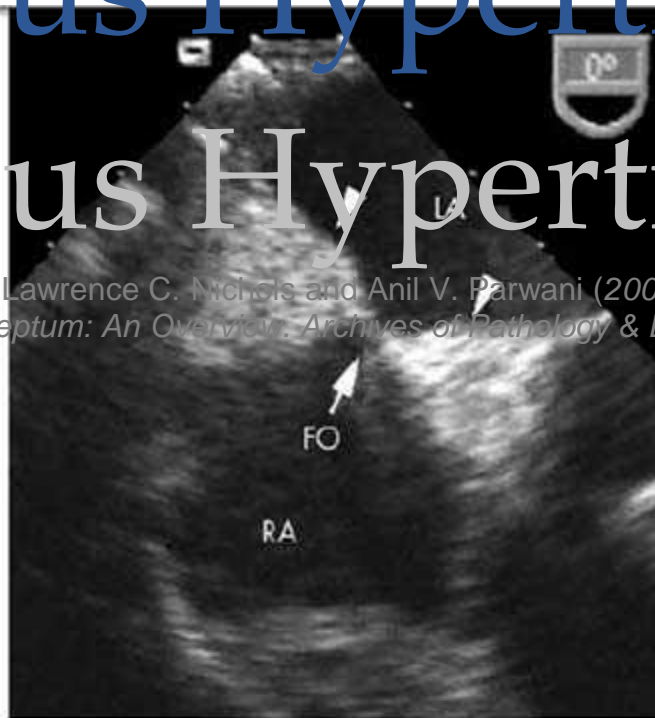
Transoesophageal echocardiogram at the mid-oesophageal level showing the classic hour glass shaped lipomatous hypertrophy of the intra-atrial septum (arrow heads). Note the clearly defined septal borders along with the bright echogenicity of thickened tissue, which clearly spares the fossa ovalis (FO, arrow).
